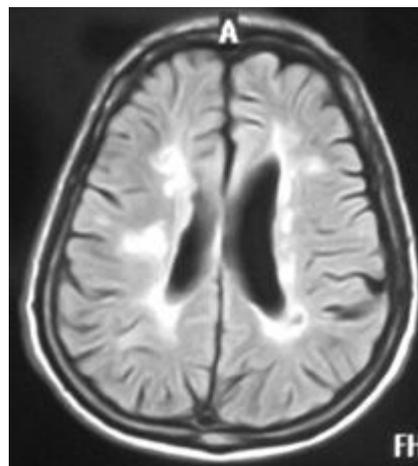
Brain MRI, T2-weighted sequences showing multiple hypersignals in the periventricular white matter
